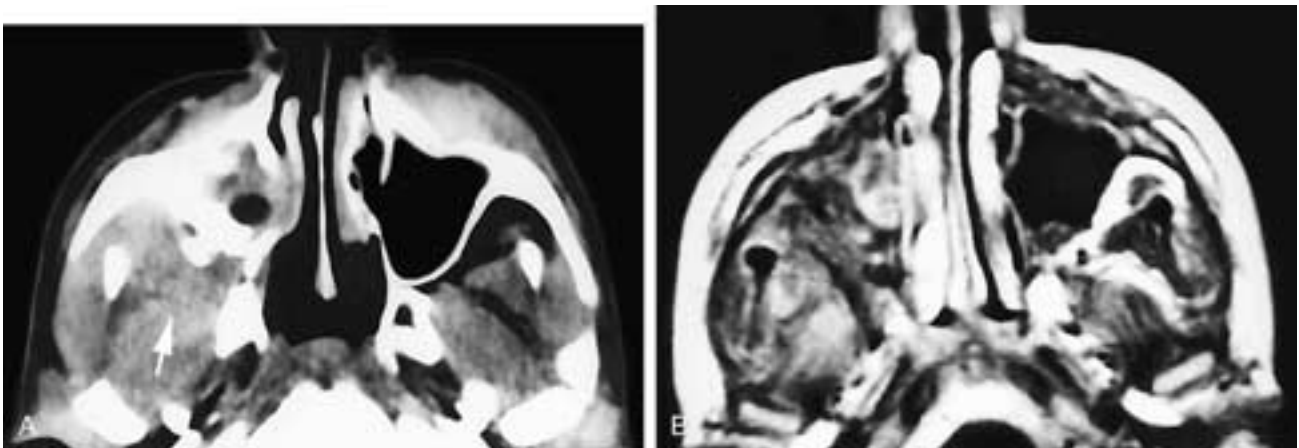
Axial CT scan A shows an infiltrating lesion in the right infratemporal fossa (*arrow*), thickening of the right maxillary sinus bony walls, and soft-tissue disease in this sinus. An axial T1-weighted MR image B shows the soft-tissue disease; however, the thickened, sclerotic bone is almost undetected. This patient had an antral pseudotumor.
